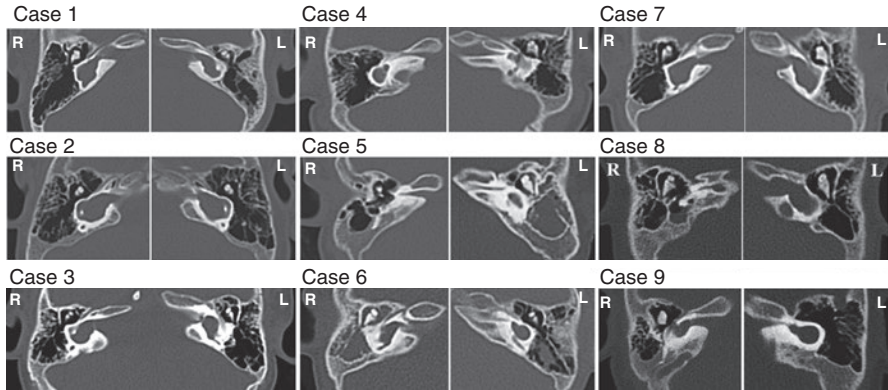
CT imaging of the temporal bones of nine infants with CC deformities with or without cochlear nerve deficiencies. The magnitudes of the cavities and the diameters of the internal auditory canals are different in each case
